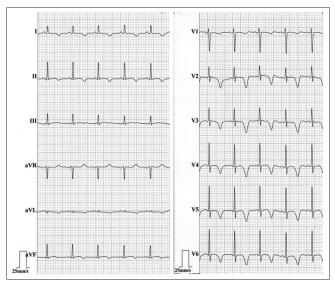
Echocardiography showing sinus tachycardia of 105 beats per minute with deep negative T-waves in I, aVL, V1-V6, and prolonged QTc interval
